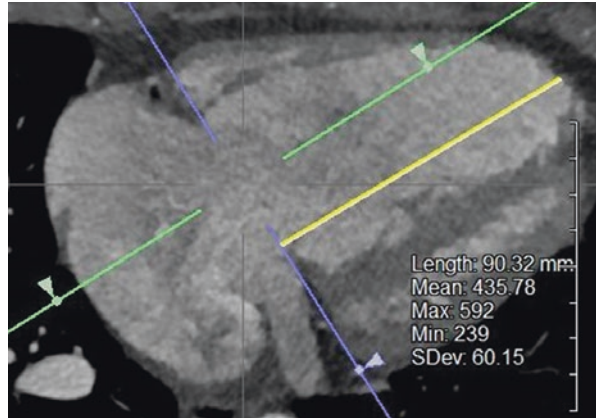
Distance between RCA and TV annulus. Computed tomography assessment of the distance between the right coronary artery and the tricuspid valve annulus. Panel (a), long-axis two-chamber view and (b), long-axis four-chamber view. The (c) short-axis view was reconstructed using the long-axis views of (a) and (b). A 3D reconstruction spatial relationship between the RCA and the TV annulus is depicted in panel D
